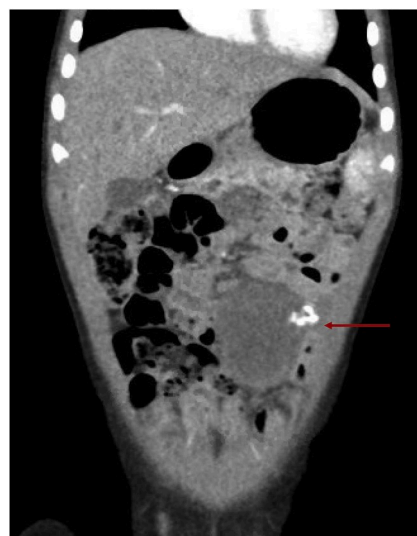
CT scan, Coronal cut, showing the tumor after three cycles of treatment.
